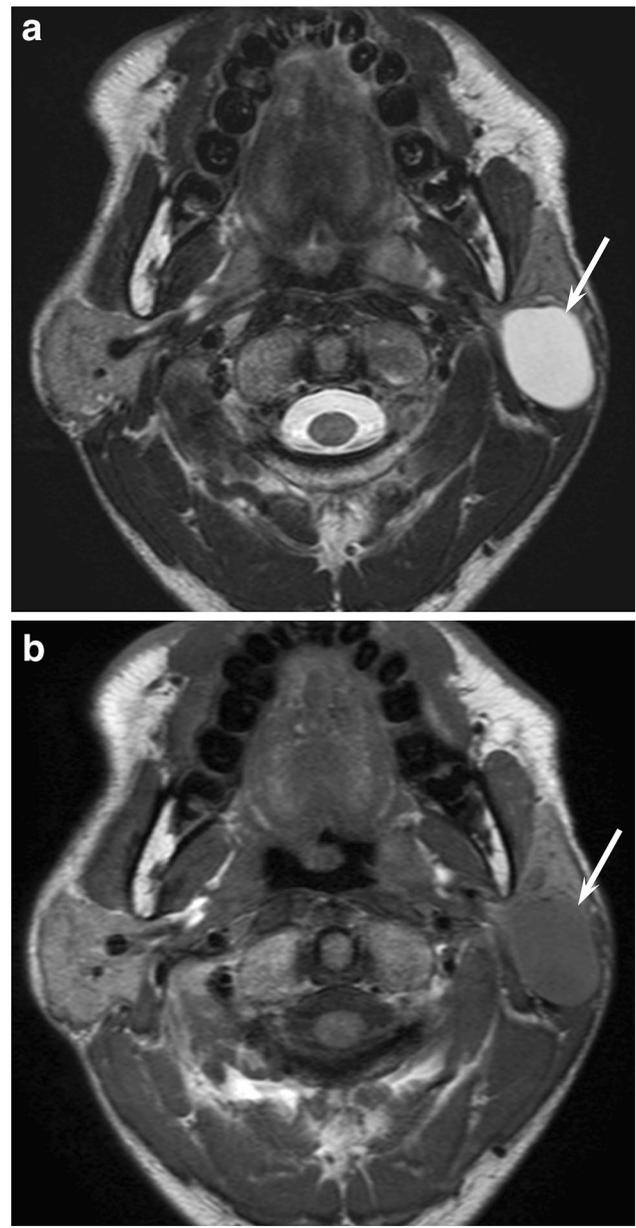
A 38-year-old man with sporadic/simple lymphoepithelial cyst. a T2-weighted image shows a thin-walled unilocular cystic lesion (arrow) in the left parotid gland. b T1-weighted image shows a slightly hyperintense cystic lesion (arrow) compared with the muscles
